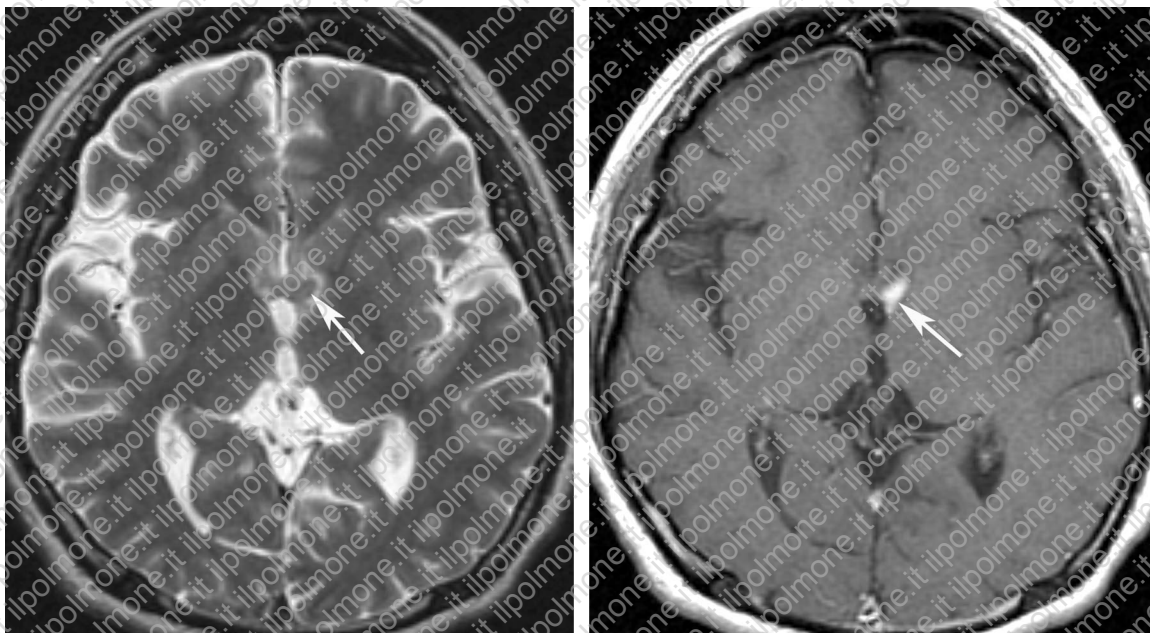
Neurosarcoidosis in a 24-year-old man who presented with diabetes insipidus. (a) Axial T2-weighted MR image demonstrates an isointense periventricular lesion (arrow) surrounded by minimal high-signal-intensity edema. (b) On a contrast-enhanced T1-weighted MR image, the lesion demonstrates enhancement (arrow).
